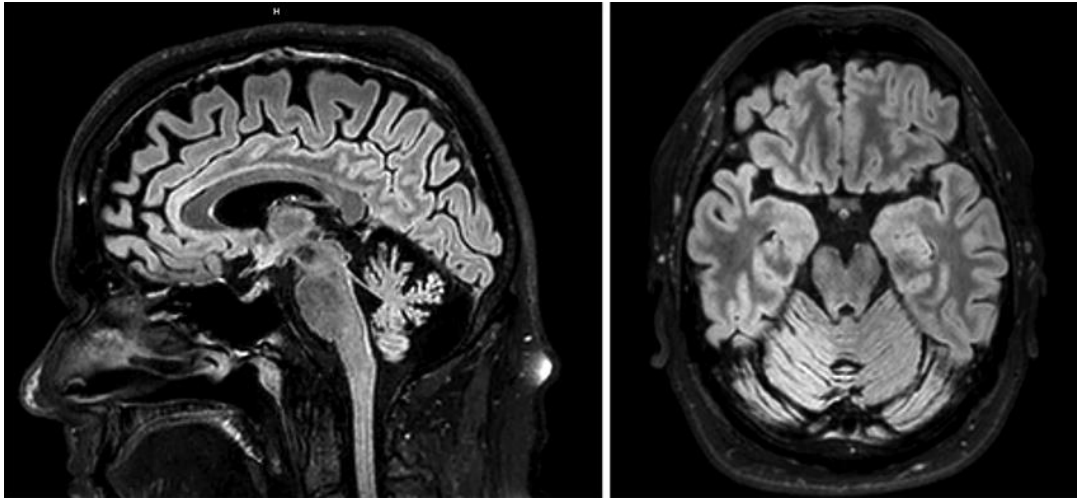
MRI midsagittal (left) and axial (right) FLAIR showing especially cerebellar atrophy.
